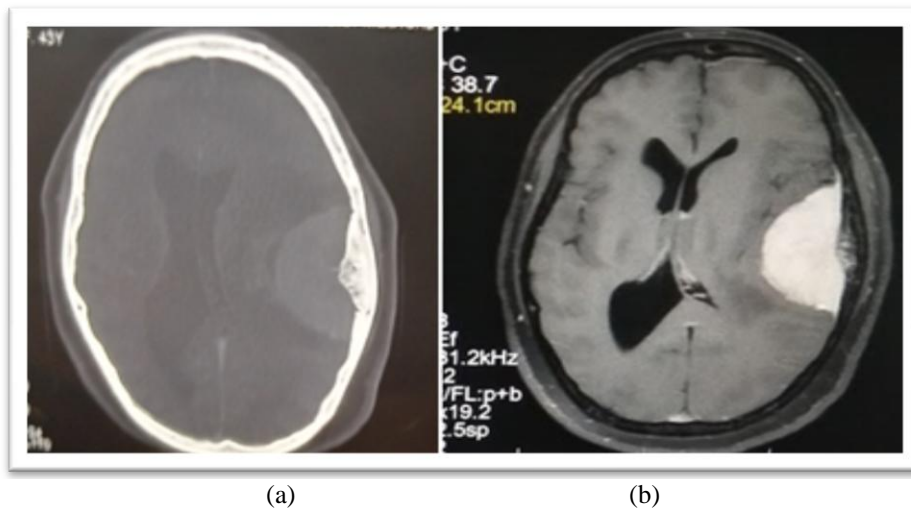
(a) Axial CT bone window showing hyperostosis in a case of convexity meningioma. (b) showing typical dural tail in T2 flair axial MRI
